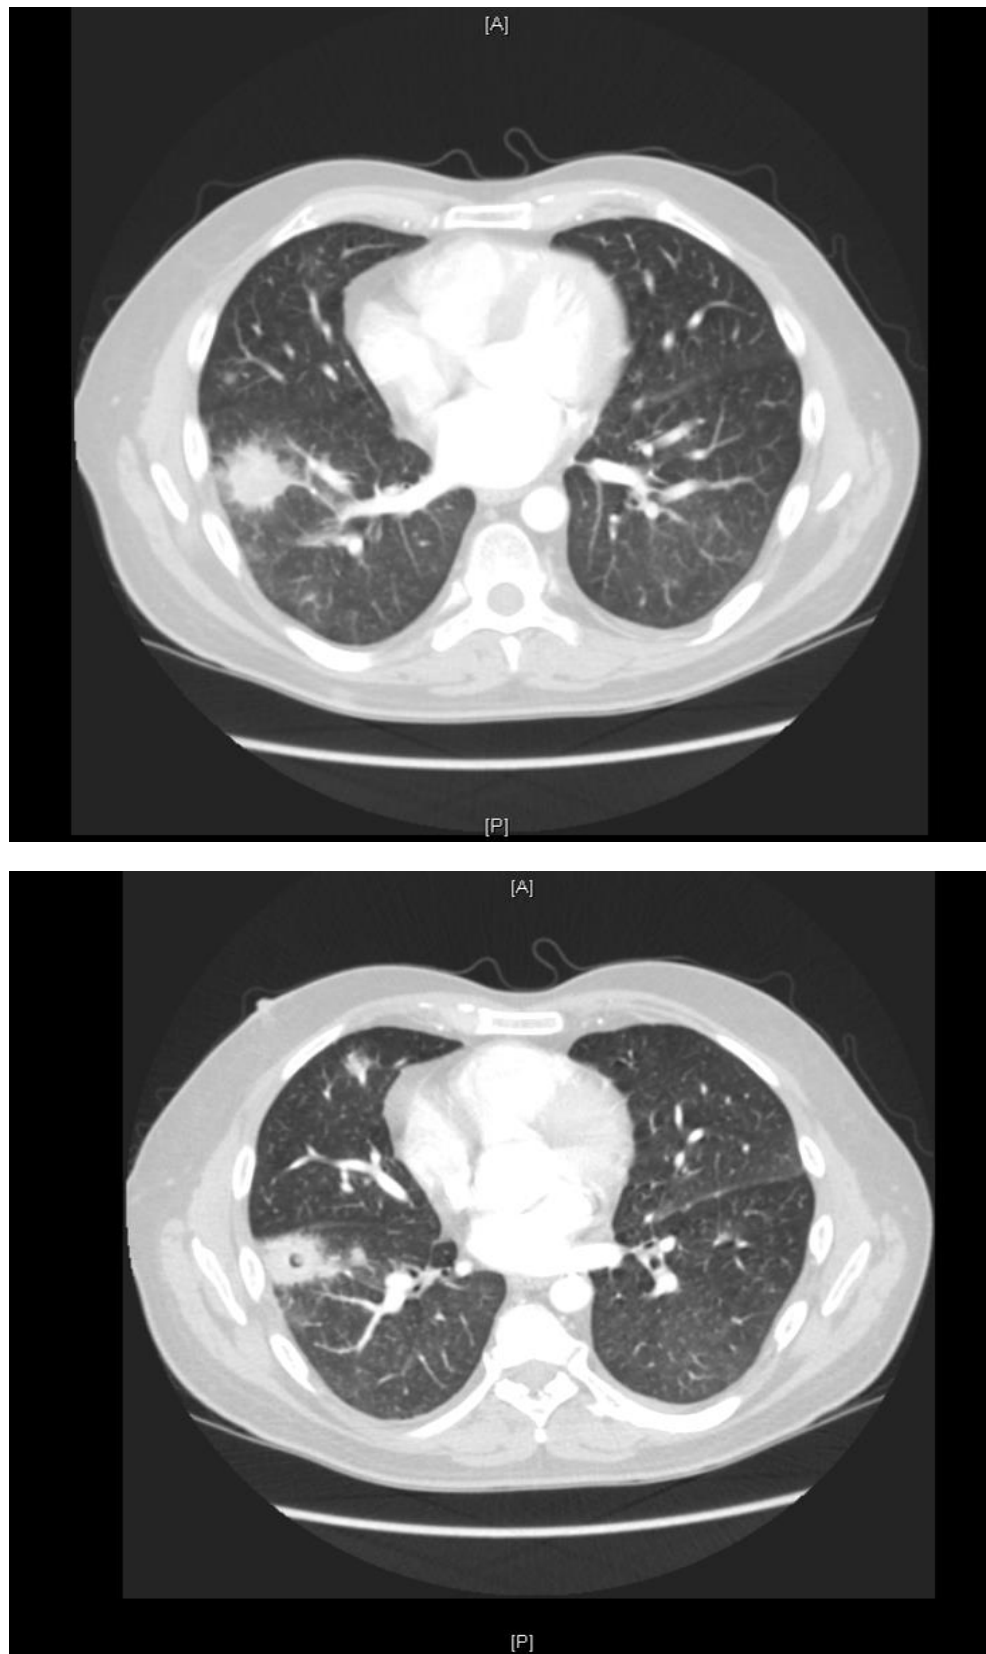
CT chest showing a macronodule with 'halo' sign (top) and air crescent sign (bottom)
